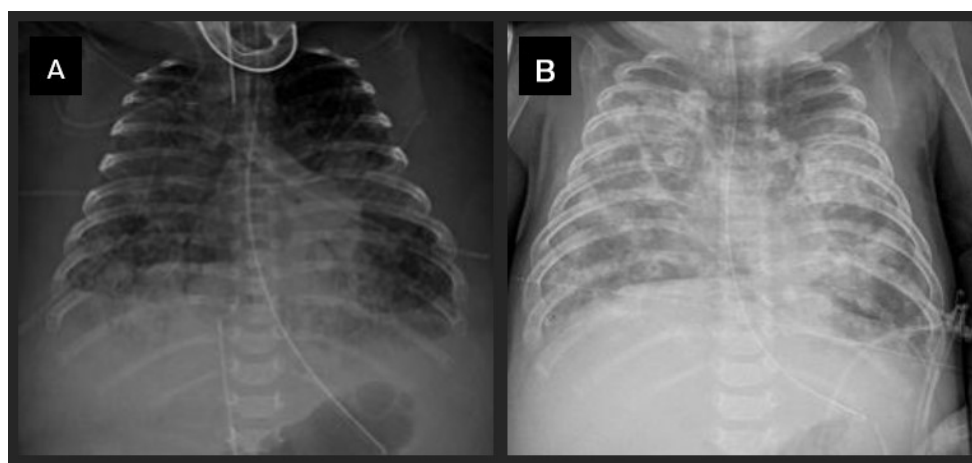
Chest X-ray at birth (A): Bilateral infiltrates, predominantly in the right lung. Chest X-ray at 60 days (B): Pulmonary nodules consistent with miliary tuberculosis.
